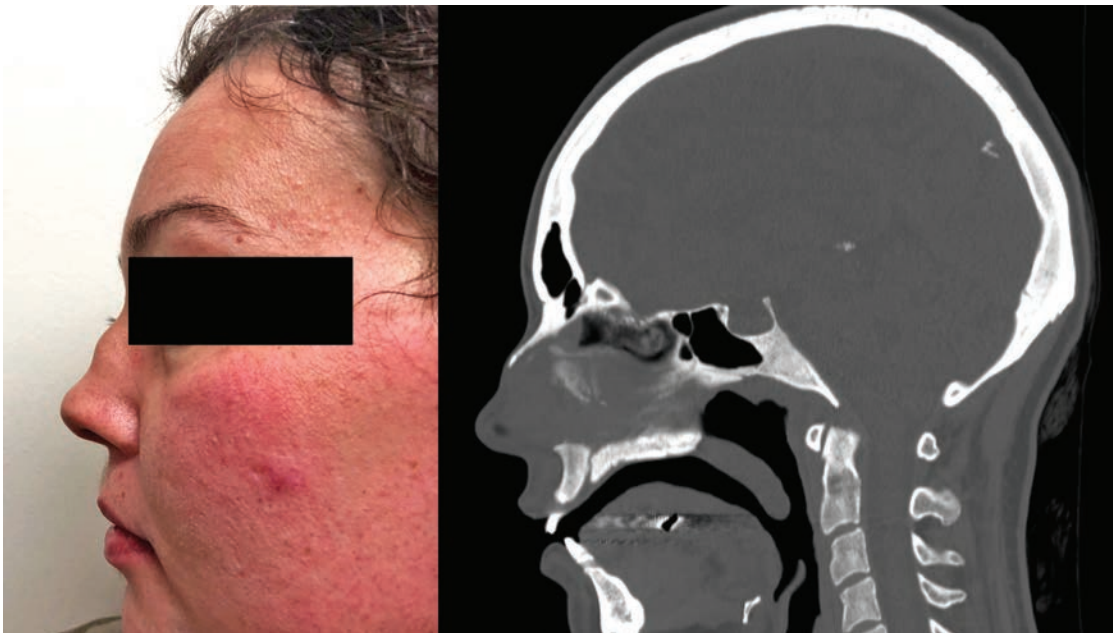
Saddle nose deformity with the corresponding sagittal CT scan view. CT: computed tomography.
